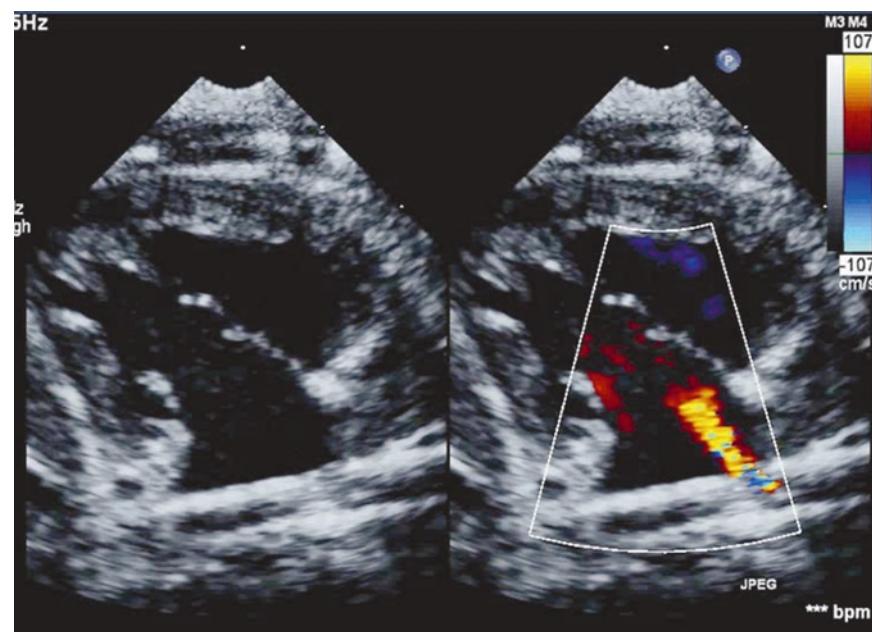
Bicaval transesophageal echocardiography (TEE) views (left black and white, right color-flow doppler) of a double-lumen ECMO cannula which has been placed via the right internal jugular vein and the superior vena cava (bottom right of pictures). The venous inflow to the ECMO is from the distal lumen of the cannula which is positioned in the inferior vena cava (bottom left of the pictures). The oxygenated blood is returned by the proximal lumen. The return orifice of the proximal lumen is positioned with TEE so that the return flow (yellow jet in doppler picture) is directed toward the tricuspid valve (center of pictures). (Photo courtesy of Avalon Laboratories, LLC. Grand Rapids MI.)
